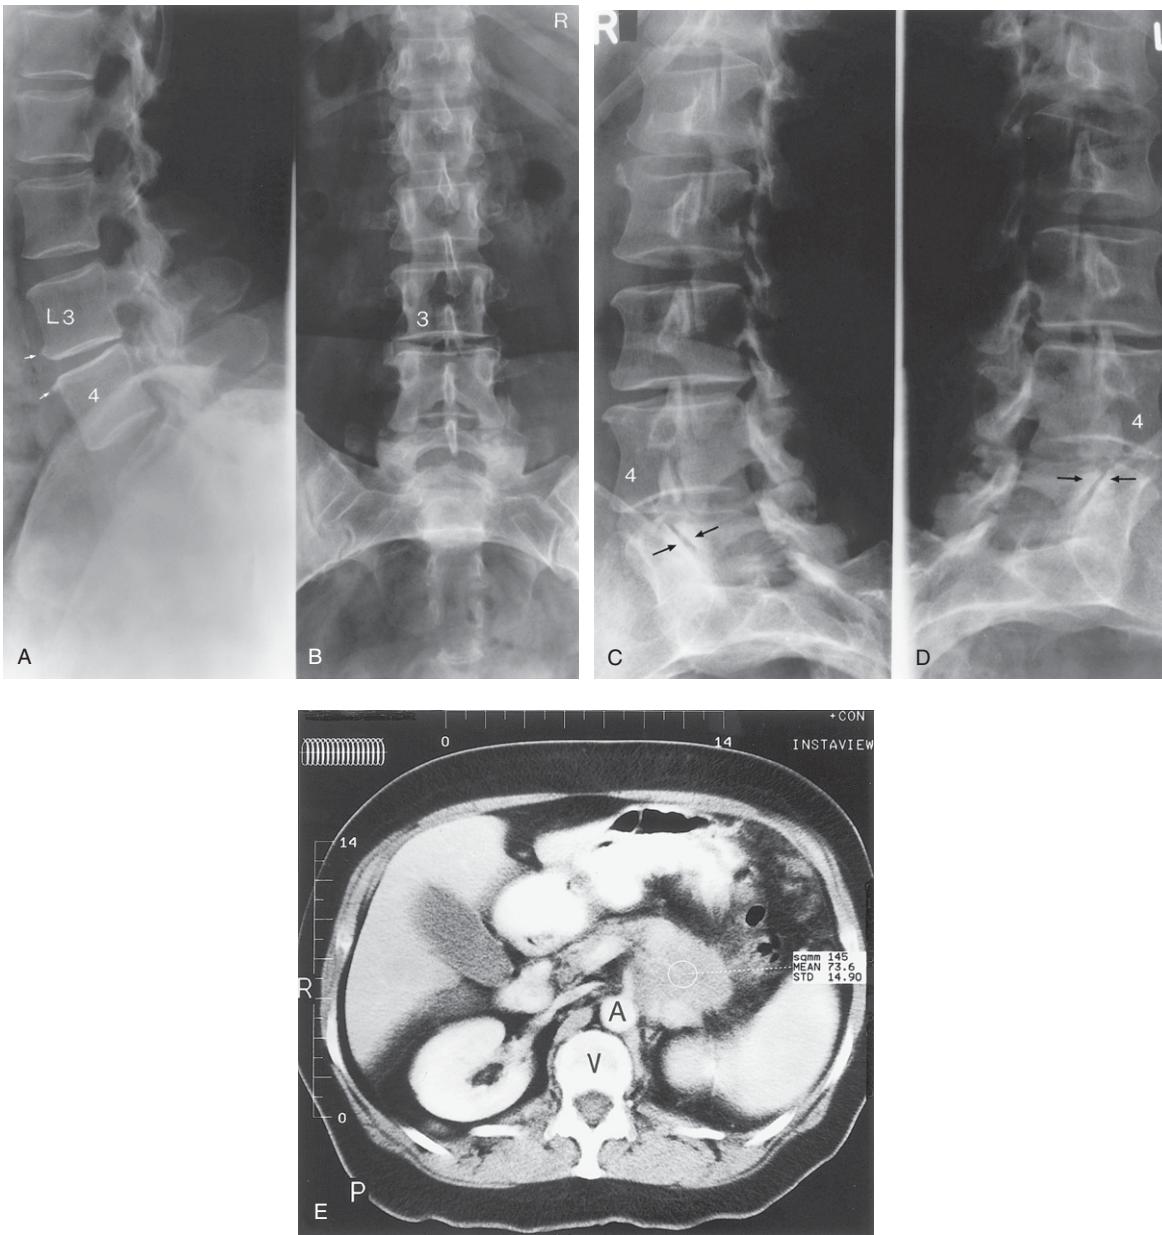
(A–D) The plain X-ray films were taken in the erect posture. The lateral lumbar spine image (A) shows disc thinning at the L3–4 level with anterior lipping (small white arrows) of the vertebral bodies adjacent to the intervertebral disc space. (C) and (D) represent the right and left oblique images and show zygapophysial joint facet early osteoarthritis (black arrows) at the L5–S1 level with some imbrication (subluxation) of the opposing facet surfaces at the L3–4, L4–5 and L5–S1 levels. (R = right side of patient.) (E) CT axial image through the upper abdomen, with contrast, showing the pancreatic tumour (with a circle placed over part of it), the adjacent proximal aorta (A) and vertebral body (V). (R = right side of patient.)
